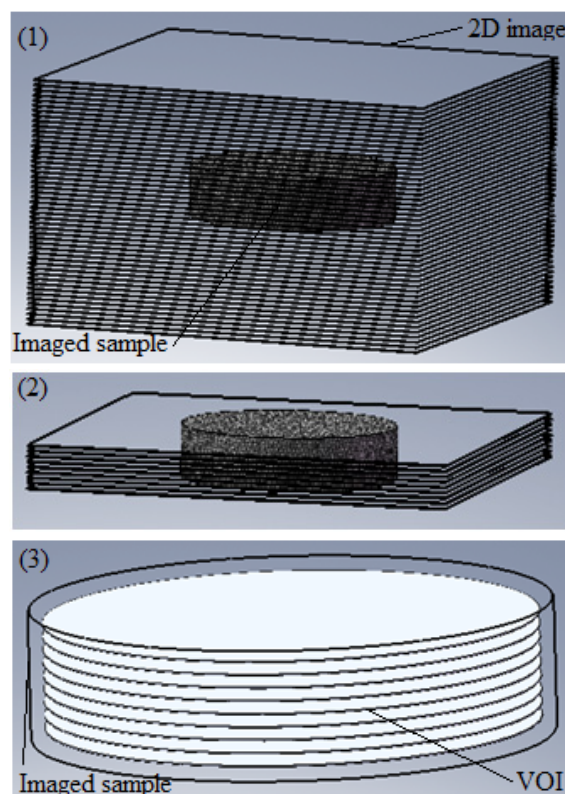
Principle of volume selection from 2D image set. Volume of scanned sample in measuring field of CT device (1), extra slices are cropped (2) and empty space from each remaining 2D image is cut (3) resulting volume which is slightly smaller than sample volume. The pictures were modelled using the CAD programme during the present study.
